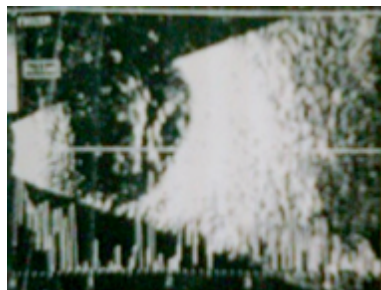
B-scan ultrasound image showing the subretinal location of the lens
